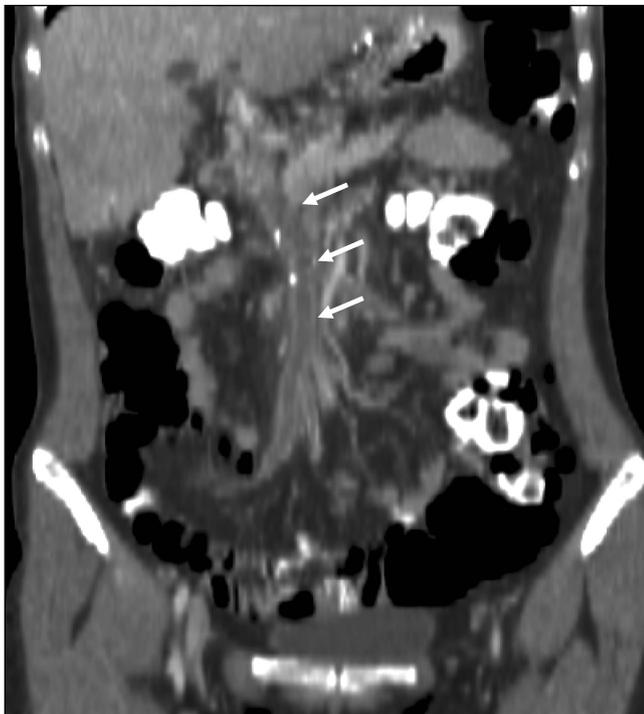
Coronal oblique reformation of the abdomen from an oral and intravenous contrast-enhanced computed tomography scan acquired in the portal venous phase. Extensive hypo-attenuating material filling the slightly dilated superior mesenteric vein (arrows) and several feeding branches is consistent with acute thrombosis
